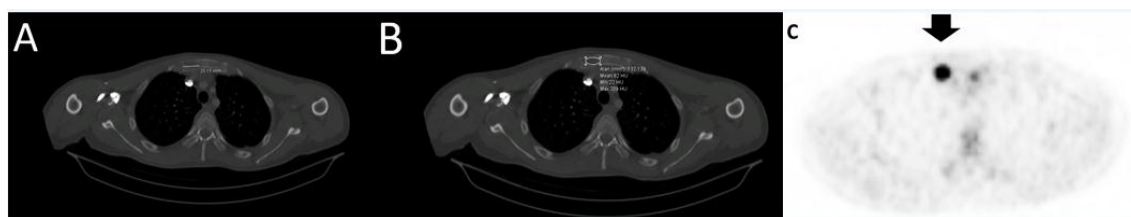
CT images of a well-differentiated liposarcoma case with multiple lytic component-rich lytic-sclerotic metastatic lesions of the manubrium and body of the sternum. The measurements were performed on the widest part of the lesion in the axial section (Figure 3A) and lesion density (Figure 3B) in the bone window. In PET-CT (Figure 3C), the SUV_{max} of the lesion was measured as 10.
